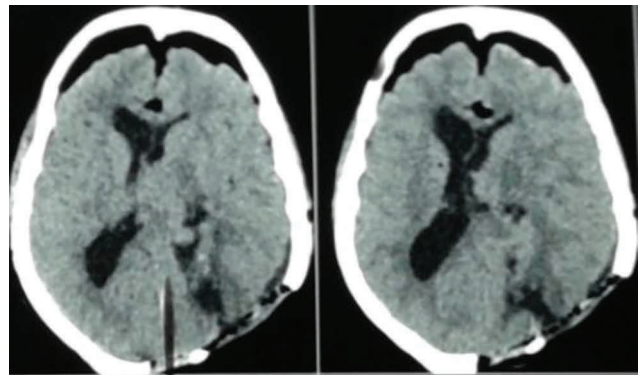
Postoperative CT scan images.
